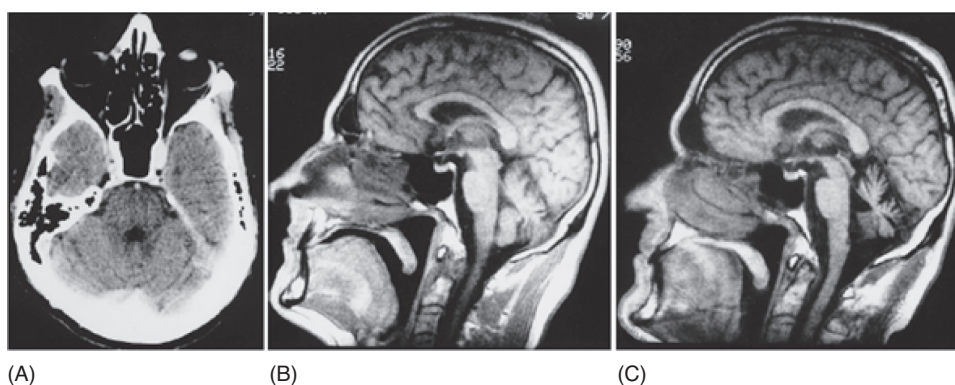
Computer tomography (CT) scans of a 45-year-old man that collapsed from exertional heat stroke on a hot summer day. He was unconscious and hyperthermic (42°C) with convulsion at the time of hospital admission. The patient remained unconscious for 5 days. (A) Normal CT scan of the cerebellum 2 weeks following collapse (B) and (C). Progression of cerebellar atrophy from 10 weeks (B) to 11 months (C). Note that hypothalamic damage was not reported in this patient. Reprinted (with permission) from Albukrek et al. (6).
